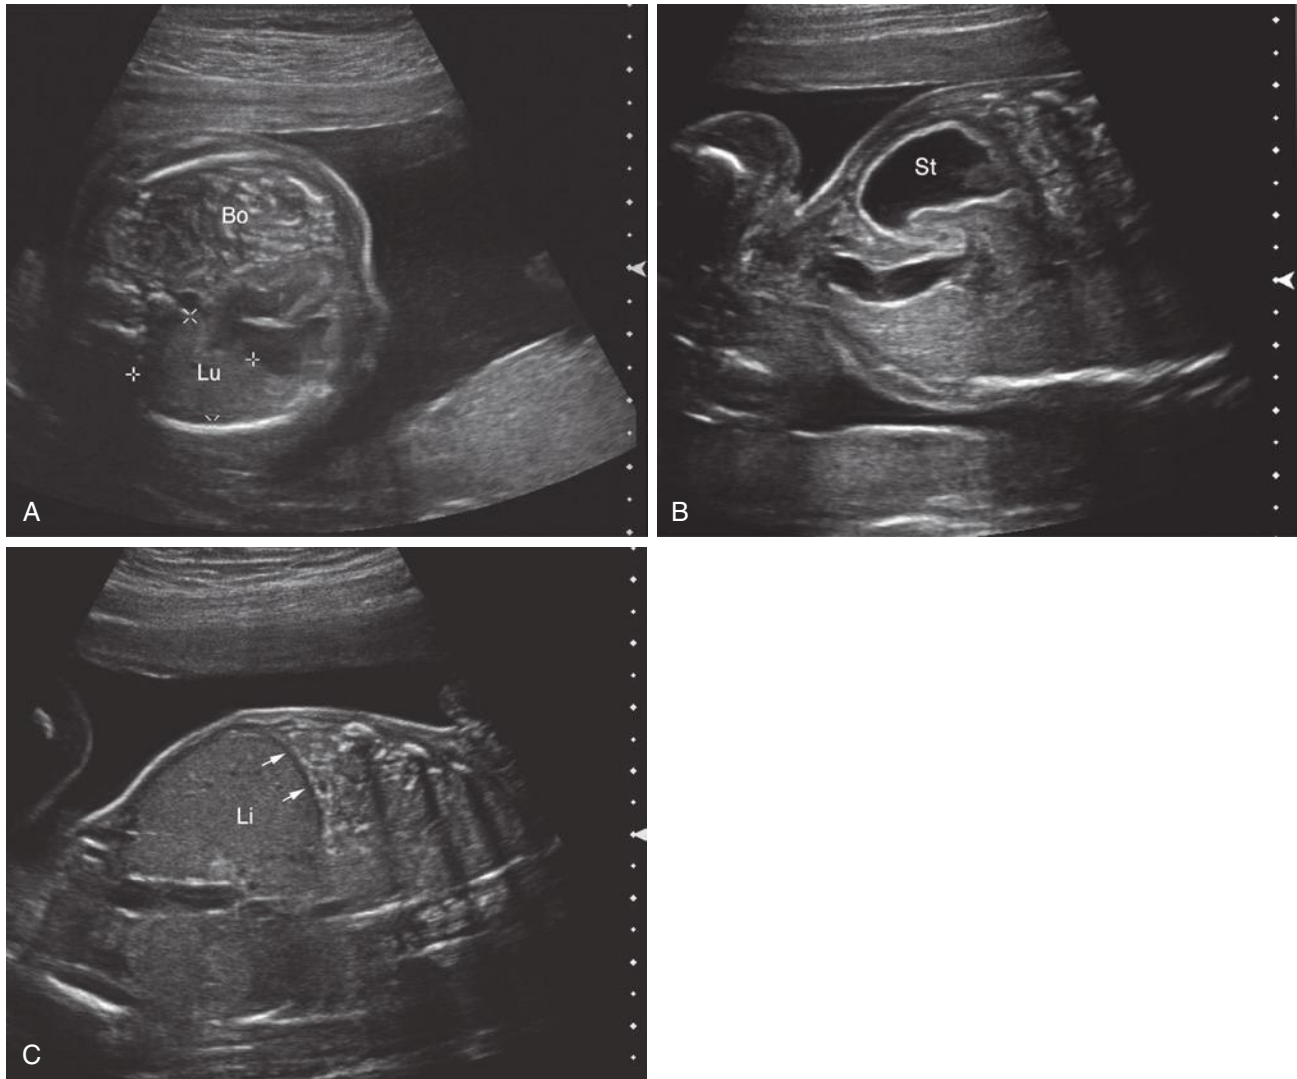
Left congenital diaphragmatic hernia. A, Sonogram of a fetus with a left congenital diaphragmatic hernia. Typically this diagnosis is made by observing the fluid-filled stomach within the thorax adjacent to the heart. In this case, bowel loops (Bo) fill the left hemithorax. Electronic calipers are placed measuring the right lung (Lu). These dimensions are needed to calculate the lung-head ratio (LHR), useful in assessing prognosis. B, Coronal plane of section of the same fetus demonstrates the stomach (St) normally positioned within the upper abdomen. C, The liver (Li) is normally positioned within the abdomen, below the diaphragm (arrows). Lack of herniation of liver into the chest is associated with better prognosis.
